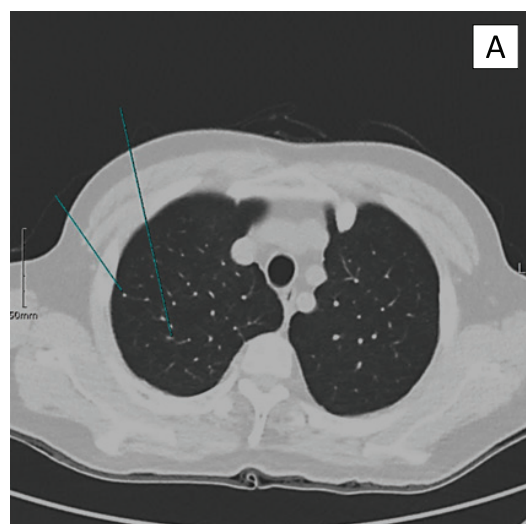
Axial lungs CT scan. (A) Two tiny nodules in the right upper lung; (B) One tiny nodule also in the right upper lung(B), mentioned as a benign lesion.
